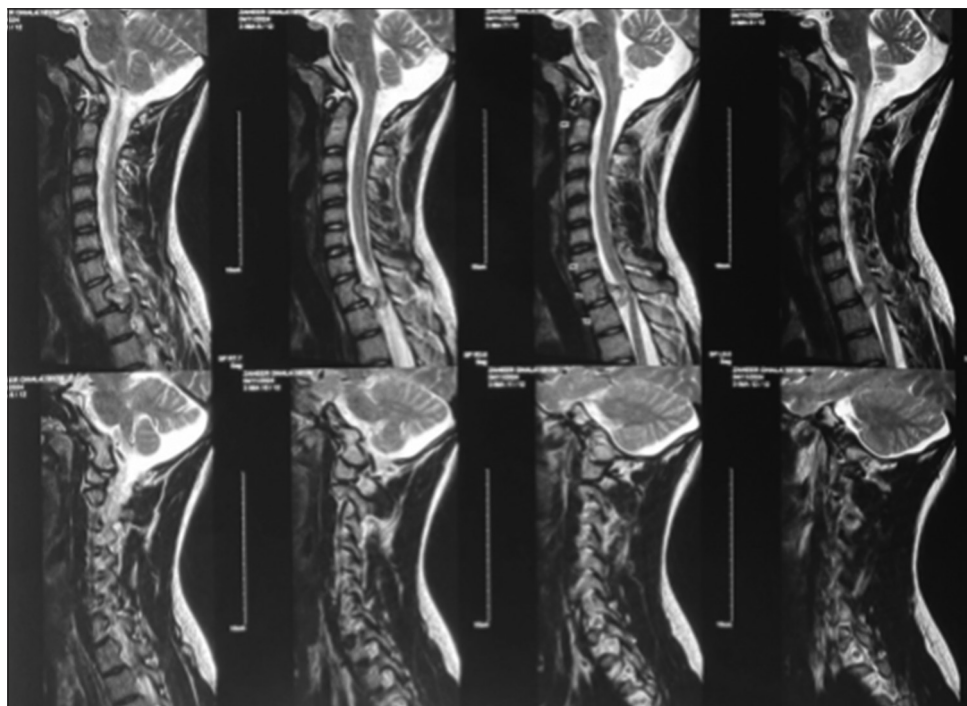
Sagittal T2 section of magnetic resonance imaging showing osteochondroma lesion arising from T1 vertebrae encroaching adjacent vertebrae causing spinal compression
